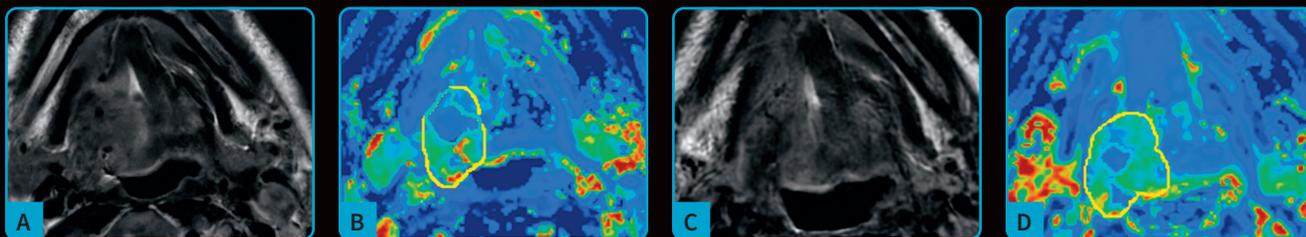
MR T2-weighted PROPELLER with AIR Recon DL before radiotherapy shows (A) a large lesion of the right base of the tongue in a patient with HPV-positive SCC cT4. (B) The K^{trans} map derived from DCE-MRI shows the presence of a hypovascular area into the tumor. (C) T2-weighted PROPELLER with the use of AIR Recon DL after 10 fractions shows a slight reduction in the tumor volume and (D) a more evident decrease of the hypo-oxygenated regions based on the K^{trans} map (-73.6%), with an increase of the entire tumor vascularization (+60.8%). Post processing was performed on GenIQ.
